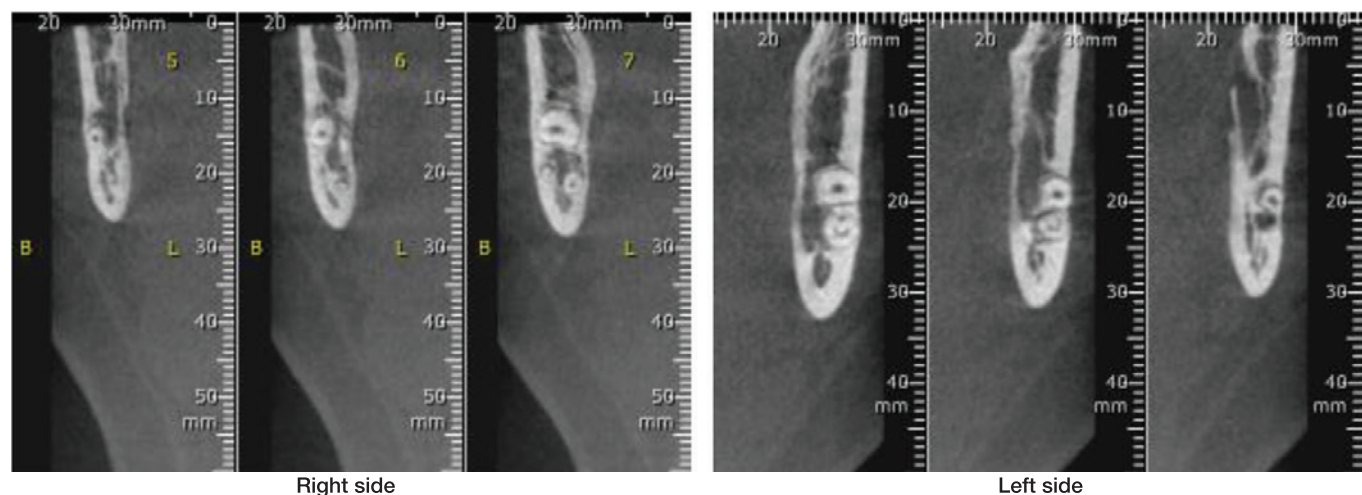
CBCT section showing the intimate relationship between lower third molars roots and mandibular canal
